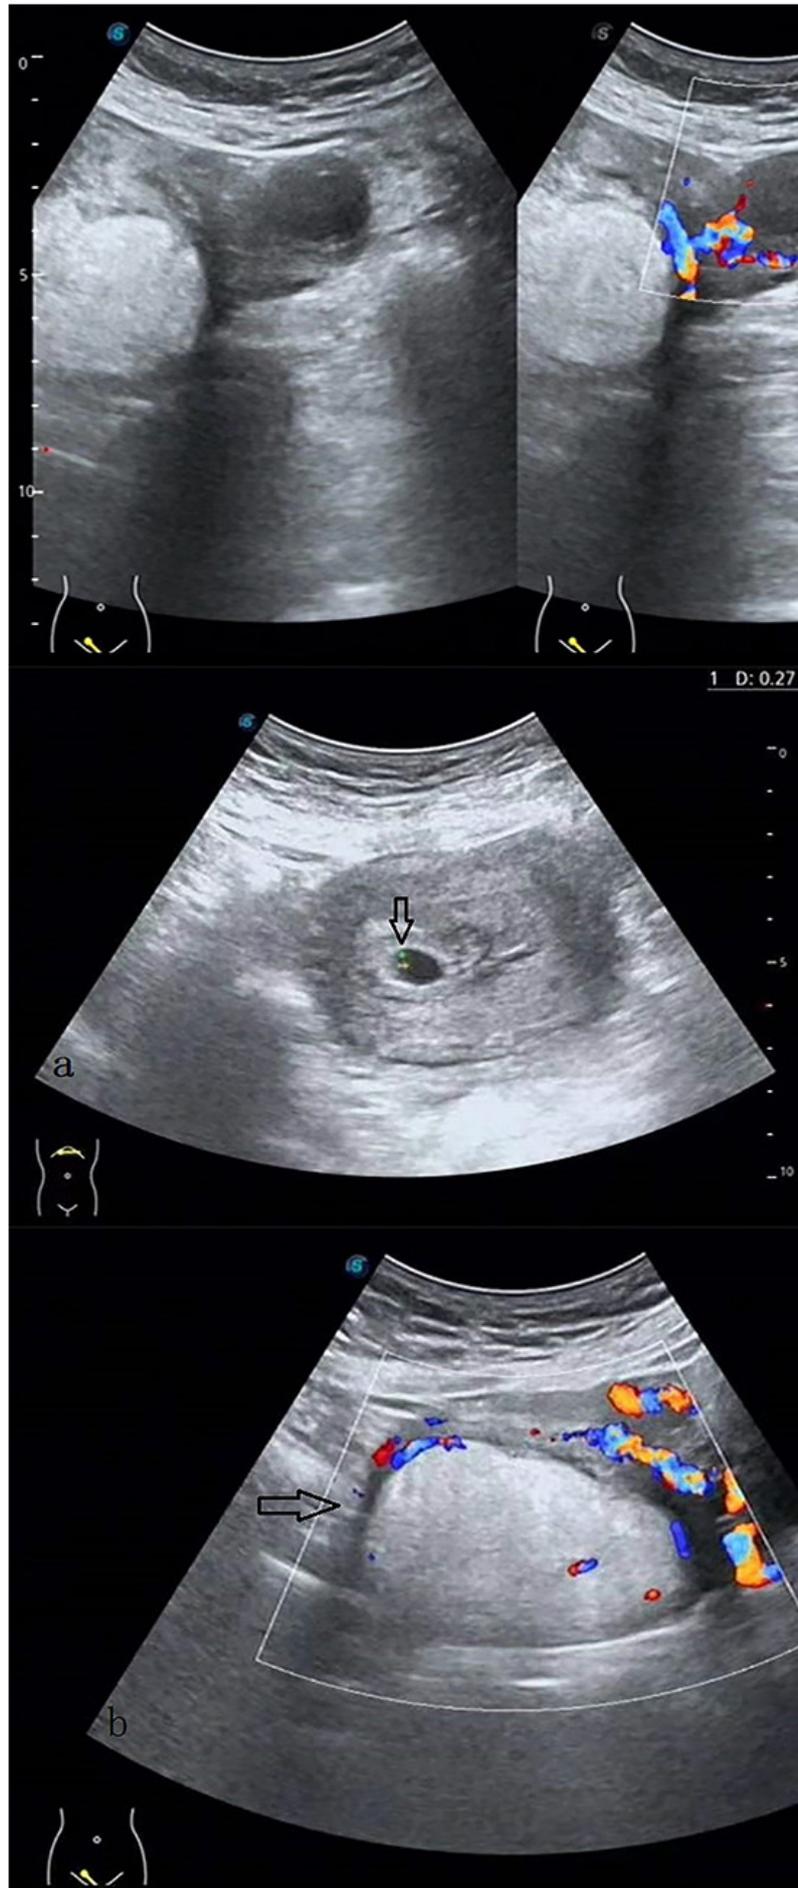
Gynecological ultrasound: (a) A gestational sac in the uterine cavity; (b) Hyperechoic lesion at the posterior wall of the uterus.
